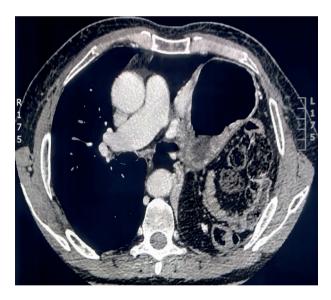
Axial CT image acquisition for soft tissue.
